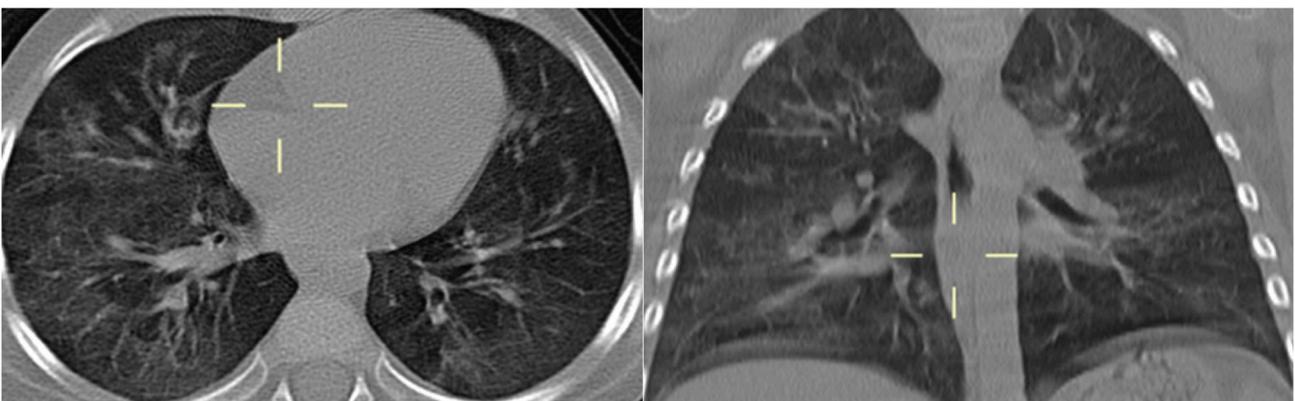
Axial and coronal CT reconstitution (patient 4)—ground-glass opacities with a typical mosaic pattern.
